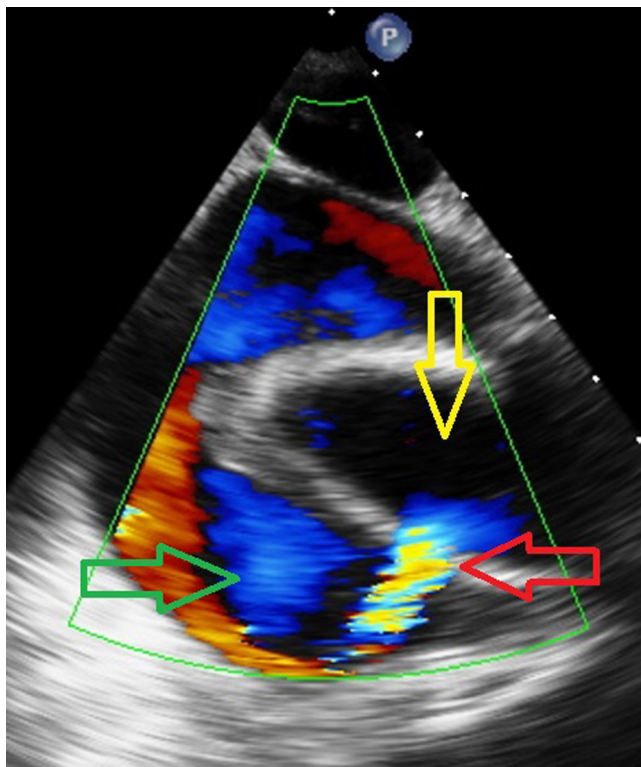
Echocardiography image of the blood flow (black arrow) between the ascending aorta prosthesis (yellow arrow) and the pseudoaneurysm (green arrow). The prosthesis defect is located at the site of the original venous bypass insertion.
